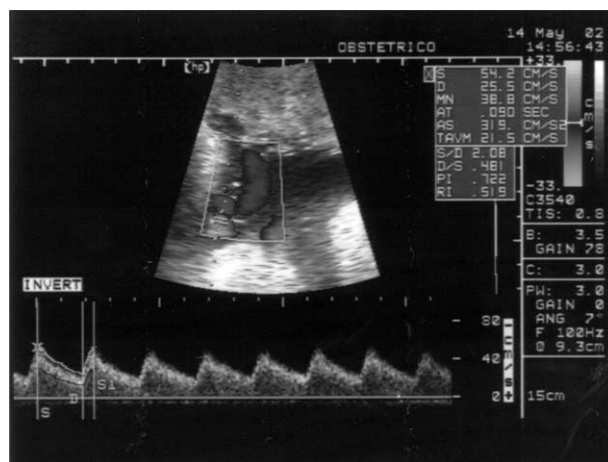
Doppler velocimetry in the umbilical artery showing the wall filter, insonation angle, site of insonation and measurement of peak systolic velocity (S), end-diastolic velocity (D) and resistance index (RI).
